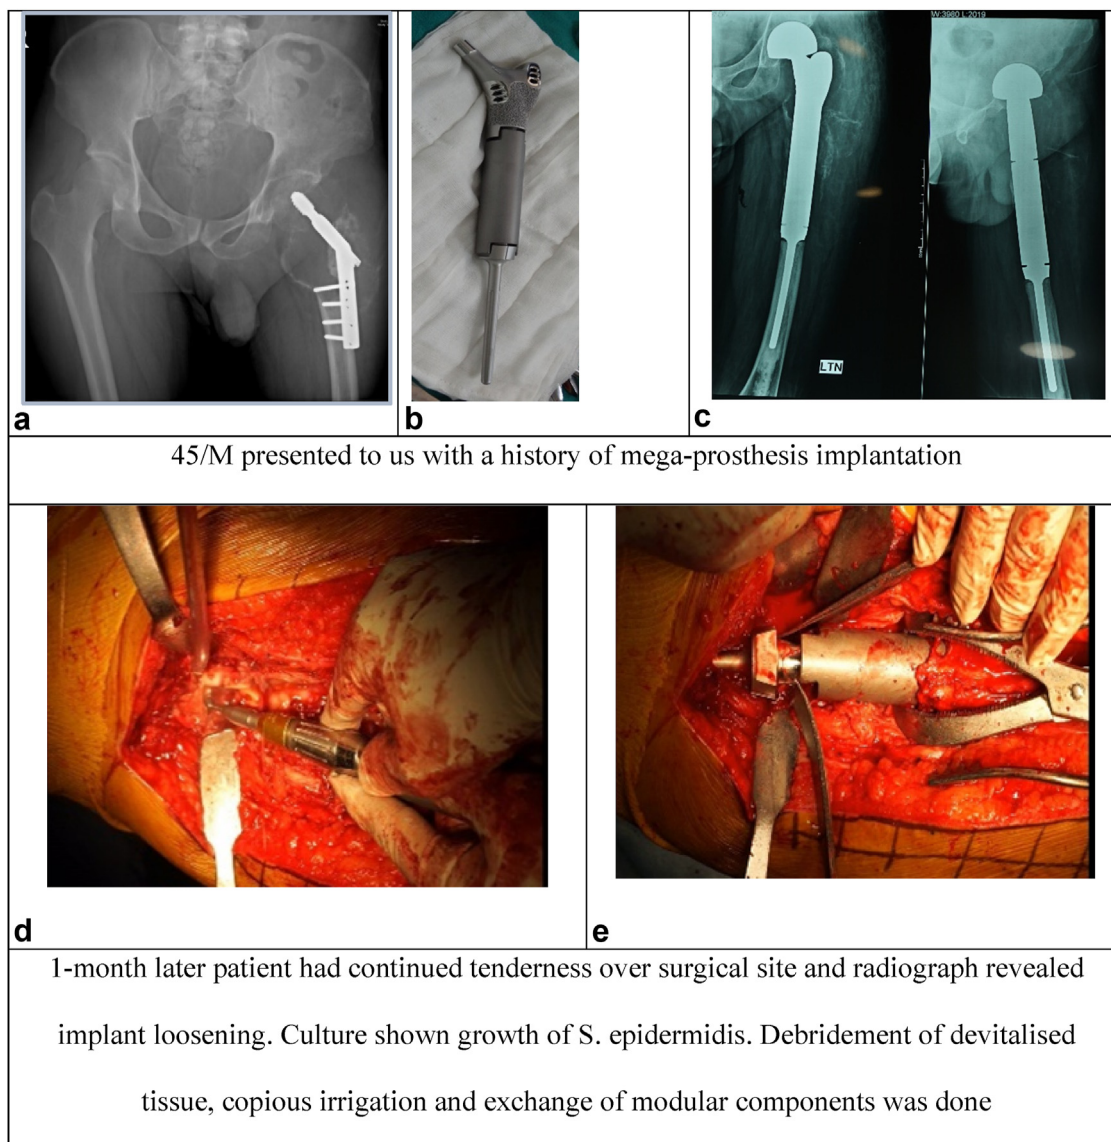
Case III, a 45-year-old male patient, presented to us with a history of megaprosthesis implantation (a, b, and c). One month later, the patient had continued tenderness over surgical site and radiograph revealed implant loosening. Culture showed growth of *S. epidermidis*. Debridement of devitalized tissue, copious irrigation, and exchange of modular components was done (d and e). At 3-year follow-up, figure shows a well-seated implant; patient is carrying out all routine daily activities without any complaints (f, g, and h).
